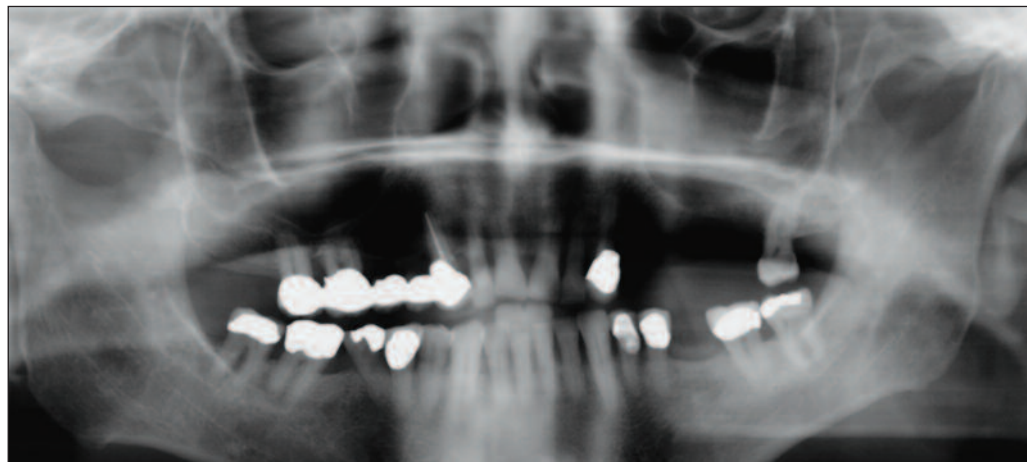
Case 1: Panoramic radiograph showing edentulous on maxillary left side.
